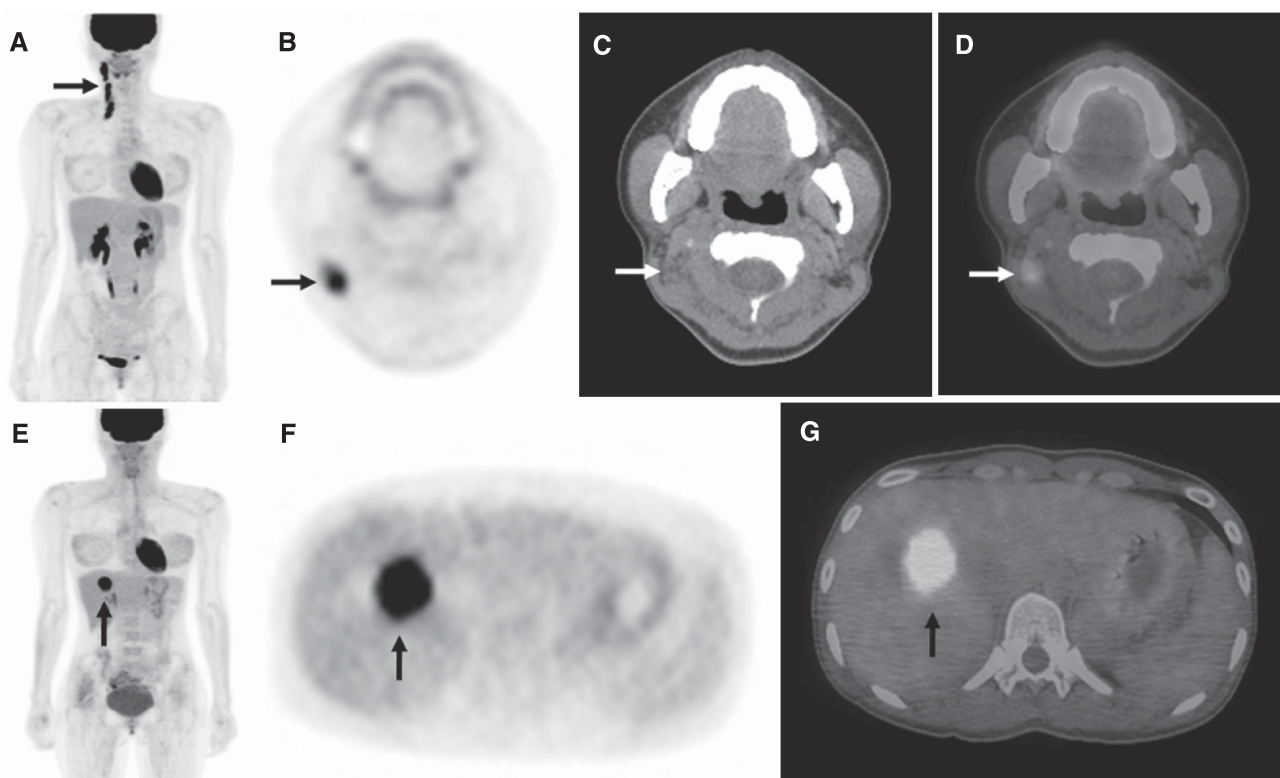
The ¹⁸F-FDG PET/CT images showing true-positive foci (arrows) of post-treatment recurrence. Whole-body ¹⁸F-FDG PET/CT scans correctly detected lymph node recurrence on the right neck at 3 months (A–D) and hepatic metastasis at 10 months (E–G) after chemoradiotherapy for oropharyngeal carcinoma. (A, B, E, and F) The ¹⁸F-FDG PET images; (C) axial CT image; (D and G) fused ¹⁸F-FDG PET/CT images.
